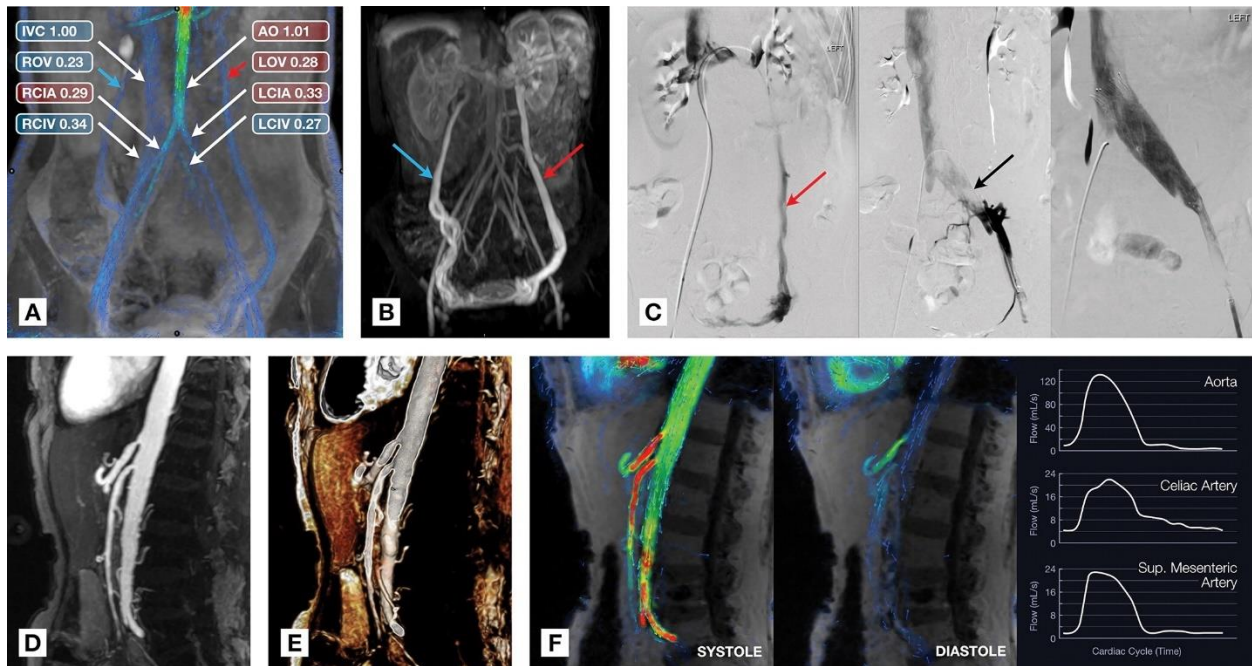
Clinical applications of abdominopelvic four-dimensional (4D) flow MRI. (A–C) Coronal oblique MRI scans obtained with postcontrast 4D flow MRI (A) and MR angiography (B) in a 24-year-old woman with Nutcracker syndrome and May-Thurner syndrome who had retrograde flow in an asymmetrically enlarged left ovarian vein (LOV) (red arrow) and antegrade flow in the enlarged contralateral ovarian vein (blue arrow). AO = aorta, IVC = inferior vena cava, LCIA = left common iliac artery, RCIA = right common iliac artery, RCIV = right common iliac vein, ROV = right ovarian vein. In C, both retrograde ovarian flow and left common iliac vein (LCIV) stenosis were confirmed during catheter angiography, with flow through the compressed LCIV (black arrow) being restored after stent placement. (D–F) Sagittal oblique images in an 89-year-old woman with a history of ischemic colitis and severe stenosis of the celiac artery and superior mesenteric artery at their origins, seen as focal vessel narrowing in the two-dimensional MR angiography image (D) and three-dimensional (3D) reconstruction (E). Postcontrast 4D flow MRI scan (F) shows similar narrowing and provides additional hemodynamic information: high flow velocity is shown in red, and persistent high-velocity flow in the celiac artery during diastole is reflected in the corresponding flow curves.
